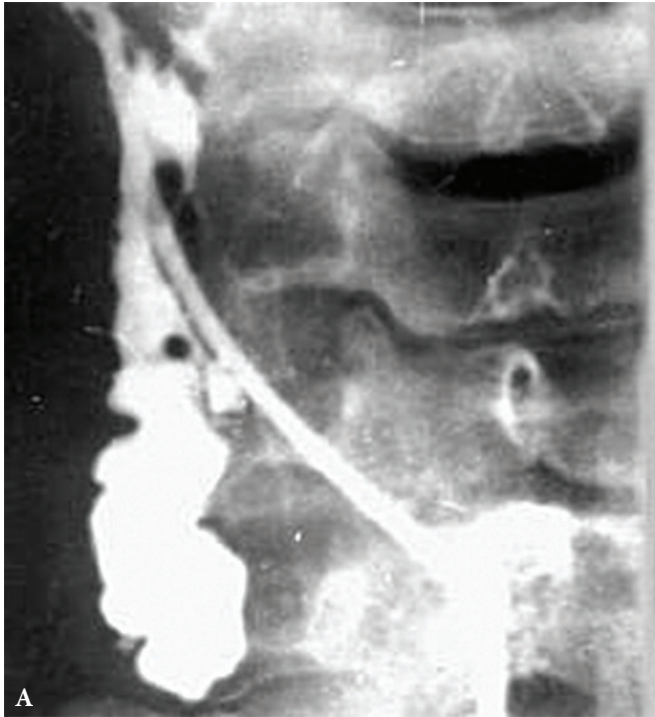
Cystogram (A) and CT images (B, C, D) of patients with BCCs.
